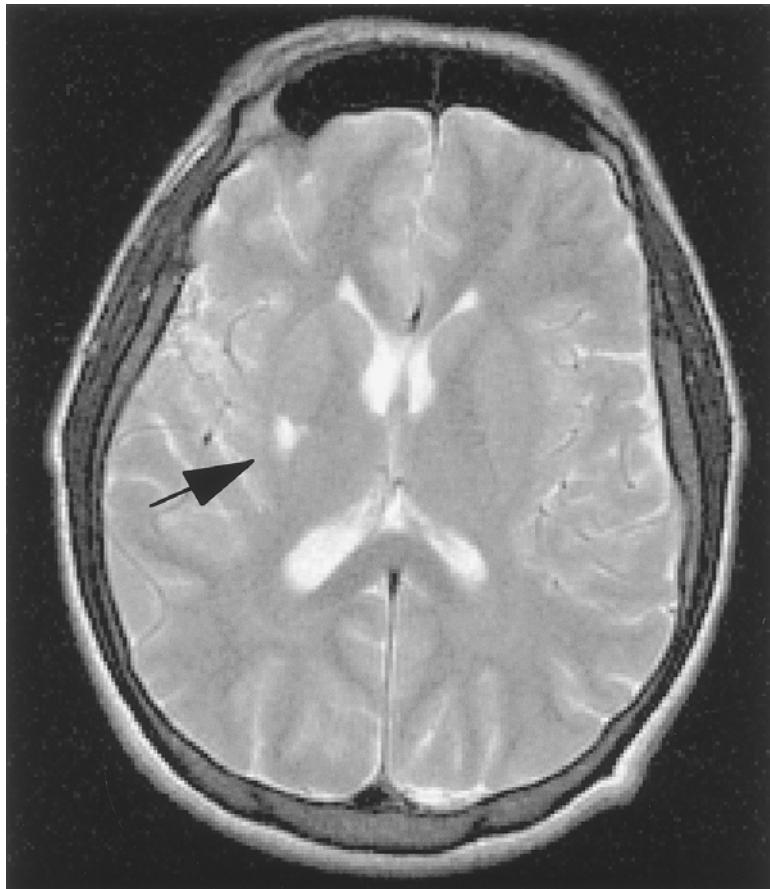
Two cases of asymptomatic strokes occurring in chronic cocaine abusers. (Left) A coronal inversion recovery image through the cerebellum shows an old infarct as a dark spot in the left cerebellar hemisphere (arrow) in a 32-yr-old woman with a history of chronic cocaine abuse. (Right) An axial T2-weighted image shows a left globus pallidus infarct in a 33-yr-old man with a 2-year history of crack cocaine smoking. (Right image courtesy of L. Chang, MD and T. Ernst, PhD, Harbor UCLA Medical Center, Torrance, CA.)
